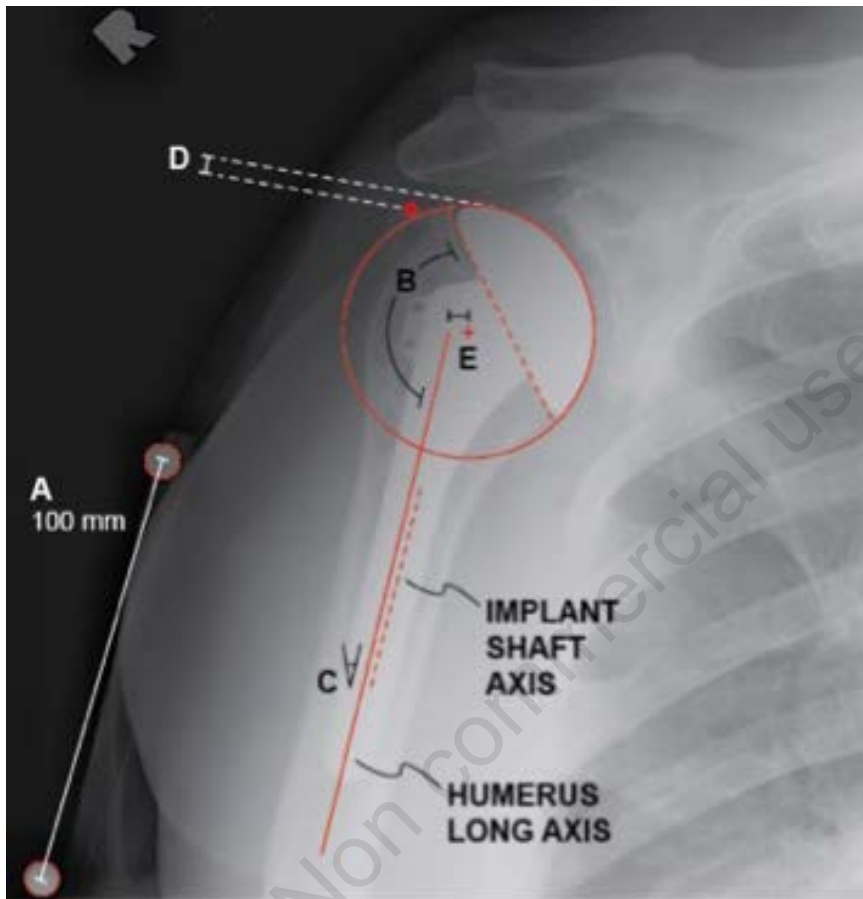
True anterior posterior plain radiograph labeled with anatomic parameters. A standard length radio-opaque marker (A) was used to scale the image. The angle between the humeral shaft axis and the base of the implant head was calculated as the humeral inclination, or head-shaft angle (B). The angle between the implant shaft axis and humeral axis was calculated as the humeral implant anatomical humeral axis (C). The distance between the user-selected point at the tuberosity and a line tangent to the implant articular surface was defined as the greater tuberosity height (D). The minimum distance between the humeral axis and center of the circle fit to the articular surface was calculated as the humeral head center offset (E).
